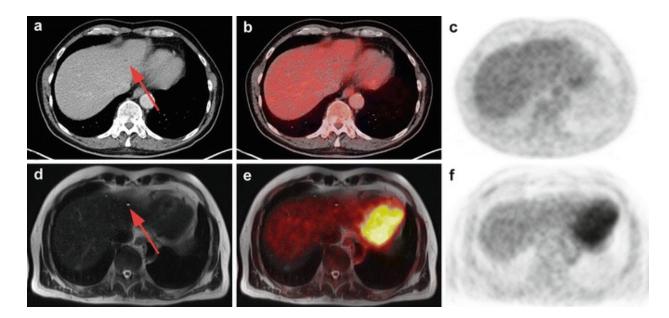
50 year old male patient suffering from malignant melanoma. Morphological, fused and PET images are displayed for PET/CT ($\mathbf{a-c}$) and PET/MR ($\mathbf{d-f}$). A lesion that is too small to specify is detected in segment II of the liver in CT (see *red arrow*, \mathbf{a}) without a correlate in PET (\mathbf{c}), the high signal in T2-weighted imaging in PET/MR (see *red arrow*, \mathbf{d}) indicates a benign liver cyst
